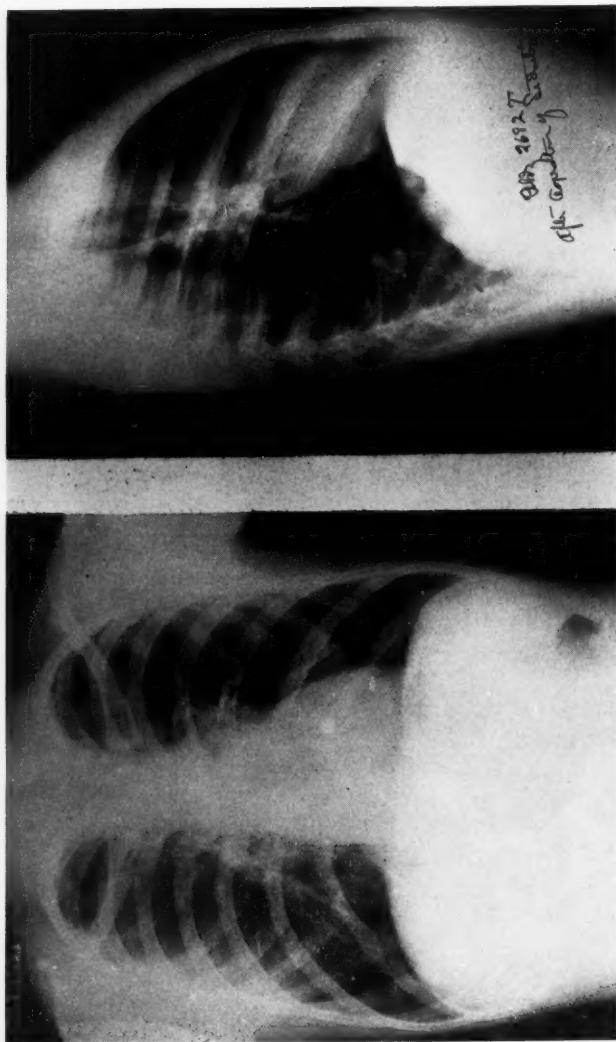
Roentgenograms of the chest made following the bronchoscopic aspiration of secretion from the left lung. The left lung has completely expanded and the heart has assumed its normal position. There is no evidence of atelectasis. Atelectasis did not recur and the lung remained clear on both physical and x-ray examination. Roentgenograms made by Dr. Karl Kornblum.
